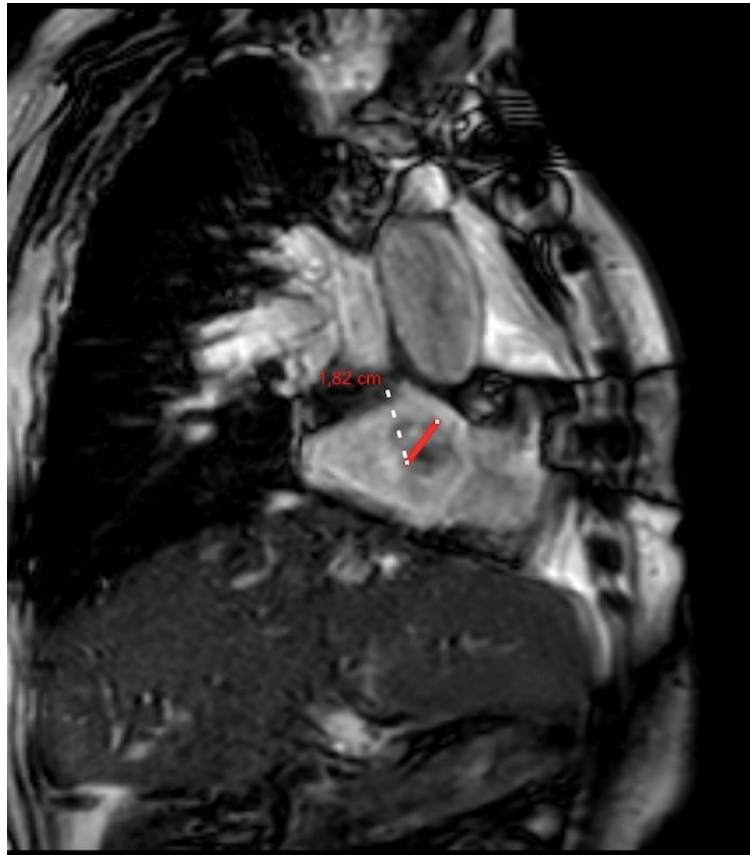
Cardiac MRI image showing a thrombus in the right atrium attached to the inferior vena cava by its appendage.
